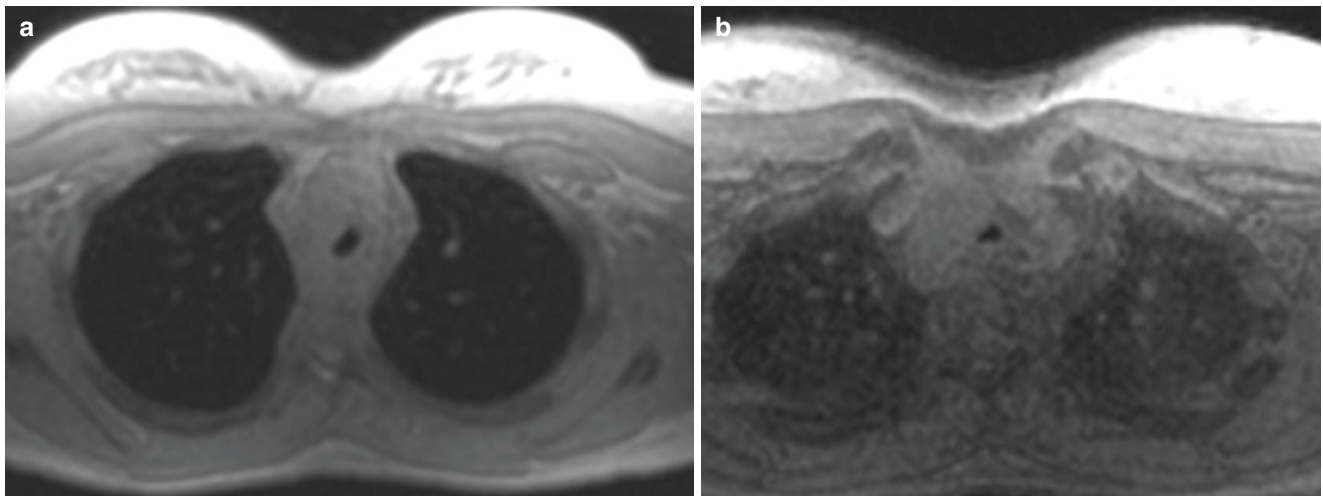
A 8-year-old girl with tracheomalacia. (a) Axial 3D SPGR MR image obtained at end-inspiration shows narrowed caliber of the trachea. (b) Axial 3D SPGR MR image obtained at end-expiration shows further collapse of the trachea
